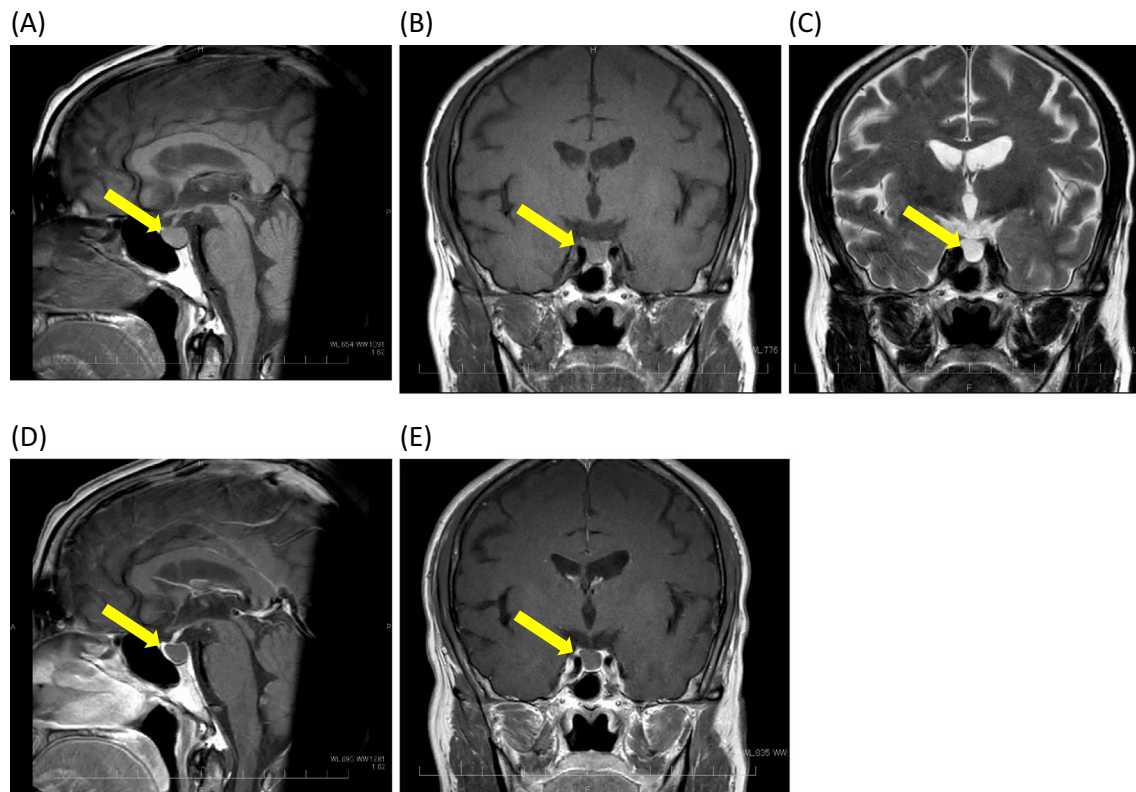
Brain MRI scan image. (A) T1-weighted sagittal image, (B) T1-weighted coronal image, (C) T2-weighted coronal image, (D) T1-weighted post-gadolinium sagittal image, (E) T1-weighted post-gadolinium coronal image. The T1-weighted image indicated slight hyperintensity, and the T2-weighted image showed a remarkably hyperintense cystic lesion in the seller region (yellow arrow). No contrast enhancement of the cyst was seen; however, a thin, enhancing rim of surrounding compressed pituitary tissue was apparent (yellow arrow). The normal T1 posterior pituitary bright spot had disappeared; however, this did not indicate the presence of central diabetes insipidus (see the text).
